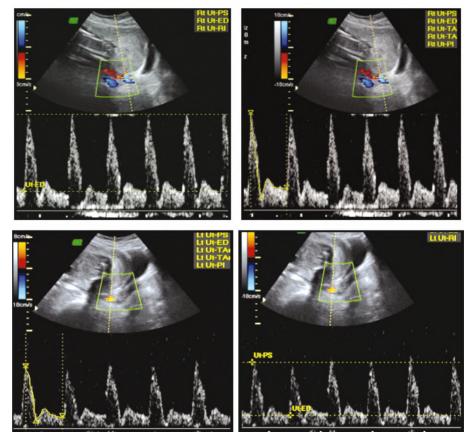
A 28-year-old female patient. The patient is pregnant and taking aldomet and aspocid for hypertension. G3P0+1 was her obstetric code. She developed preeclampsia and had preterm labour when she was 23 weeks pregnant. The right uterine artery has an abnormally high RI of 0.8 and the left uterine artery has an abnormally high RI of 0.82 on Doppler examination of both uterine arteries.
